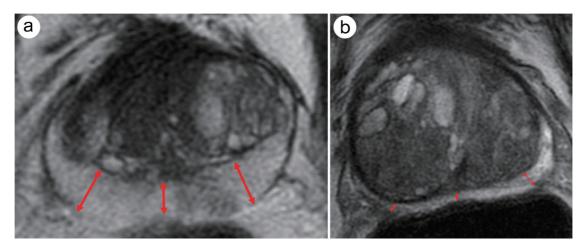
The 'compression effect' on the PZ in large prostates. (a) MRI example of a small prostate (21 cc): Axial T2 image of the mid-gland region of a prostate showing a thick relative peripheral zone (relative to (b)) delineated by the red arrows; (b) MRI example of a large prostate (124 cc): Axial T2 image of the prostate gland within the mid-gland region of a prostate showing a thin relative peripheral zone (relative to (a)) delineated by the red arrows. MRI, magnetic resonance imaging; PZ, peripheral zone.
